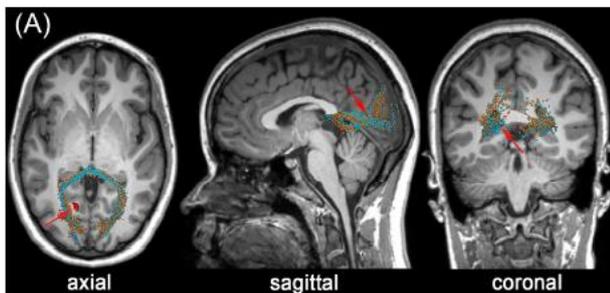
A representative sample of DTI streamlines passing through the area of a \sim four mm^3 CMB (red) in an old adult host of mTBI. Arrows show a CMB in the left hemisphere, close to a streamlined bundle belonging to the splenium of the corpus callosum. (A) Standard views (coronal, sagittal, axial) of $T1$ -weighted MRI were shown in addition to DTI glyphs related with perilesional WM streamline bundles imaged acutely (orange) and nearly six months after injury (light blue). The splenium is unusually asymmetric at both time points, with the asymmetry being most noticeable close to the CMB (inset).
